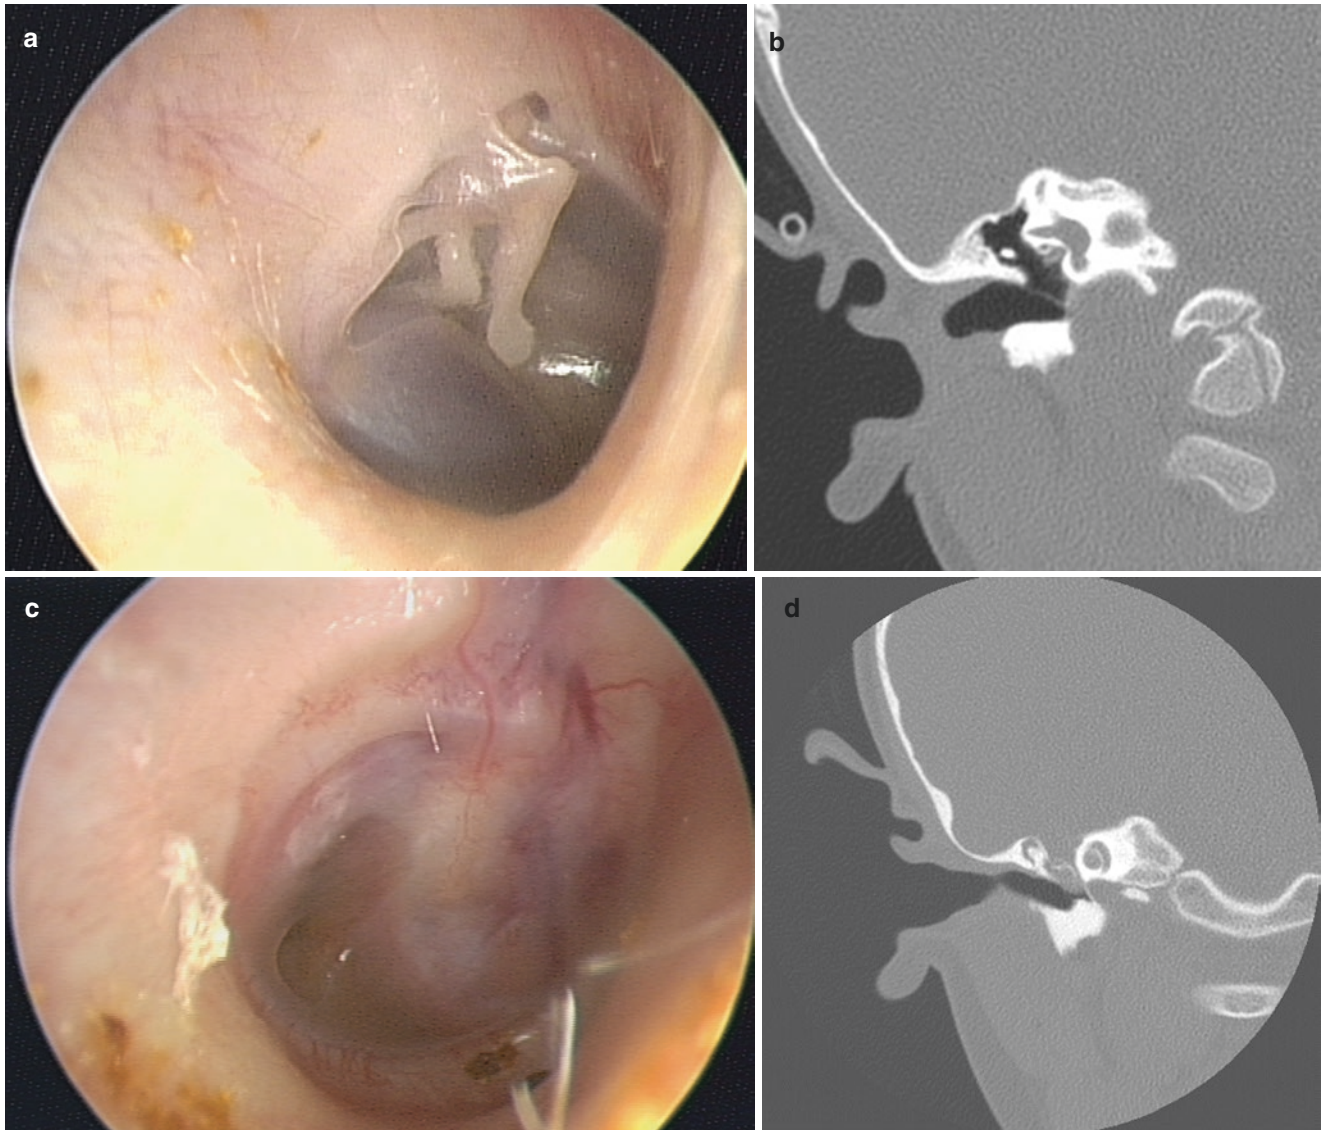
(a) Otoscopy demonstrates bluish color of inferior mesotympanum consistent with a high jugular bulb. (b) Coronal CT of right ear showing a high jugular bulb. (c) Otoscopy of right ear showing pinkish mass behind tympanic membrane found to be an encephalocele. (d) Coronal CT of encephalocele of right ear showing dehiscence of bony tegmen with soft tissue mass in the middle ear. This was visible on otoscopic exam (Fig. 4.4c). (e) Axial CT of glomus tumor showing
